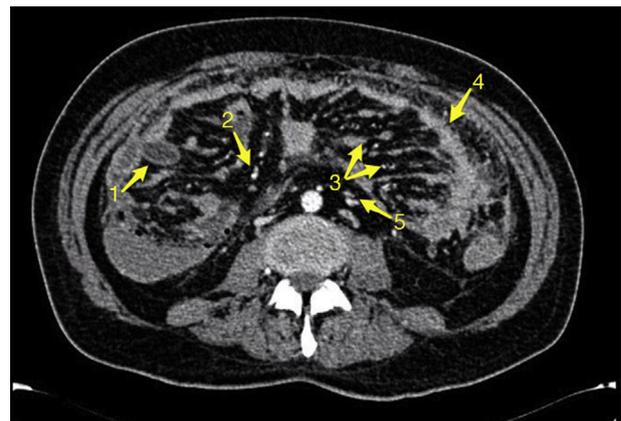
CT showing (1) blood content in jejunum, (2) multiple peritoneal implants, (3) omental cake, (4) thickening of the omentum, (5) lymphadenopathy.
